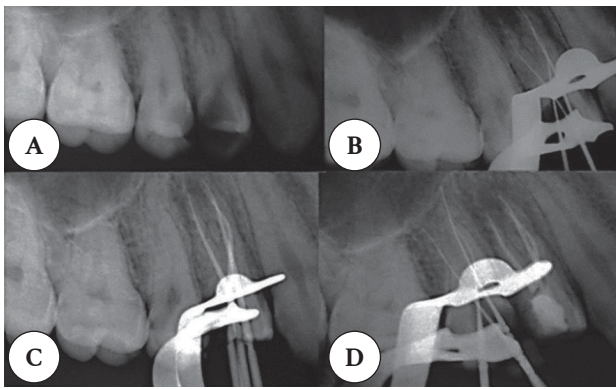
Root canal treatment sequence of an upper premolar. Image obtained from Beyraghshamshir et al. (2). A: A: diagnostic X-ray; B: conductometry; C: conometry; D: obturation of the three canals.
